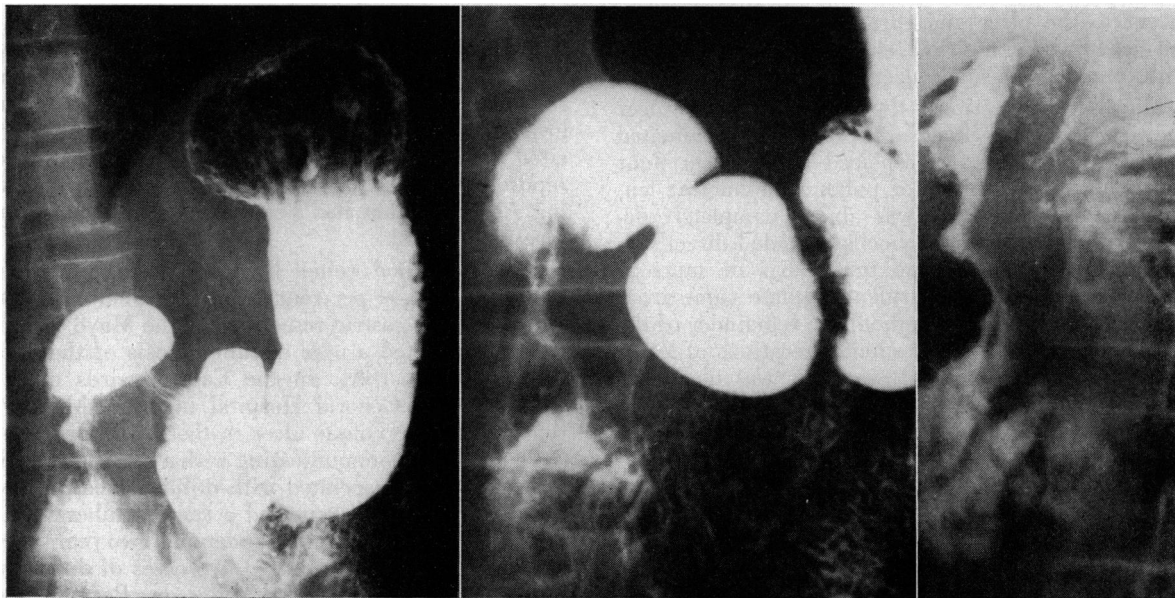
Left*, radiograph showing a long narrow infiltrating lesion of the second portion of the duodenum with ulceration. *Center*, spot film of second portion of duodenum, showing destroyed and distorted mucosa. *Right*, spot film of second portion of duodenum, showing ulceration and narrowing.
